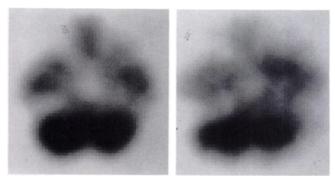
SPECT brain images (approximately 1 cm above the orbitomeatal line) of the same neurologically normal volunteer after administration of ^{99m}Tc-ECD (left) and ^{99m}Tc-HMPAO (right). All images are thresholded to their maximal pixel value and have a lower threshold of 5% and an upper threshold of 100%. Note the higher degree of non-brain background activity in the ^{99m}Tc-HMPAO images.
